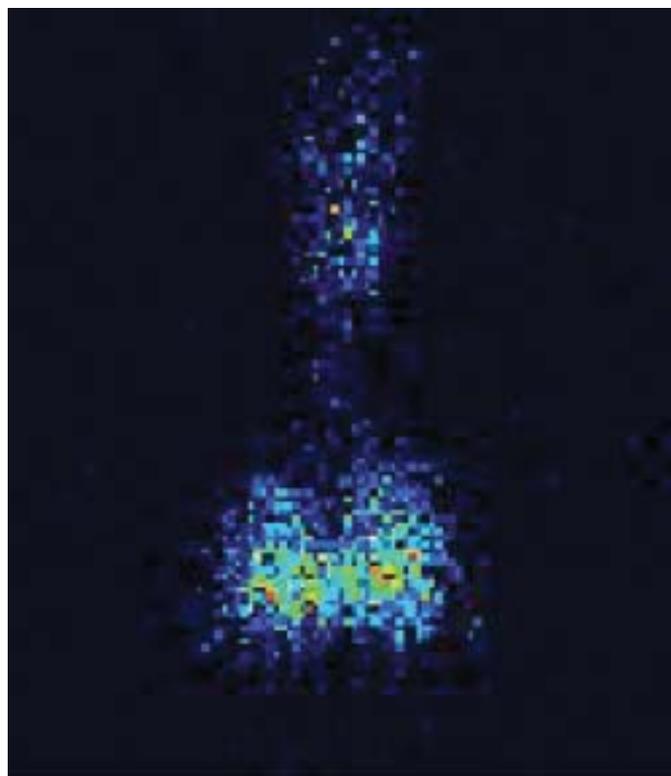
Ventral scintigraphic imaging after endotracheal spray administration showing a homogeneous pattern of pulmonary deposition.
